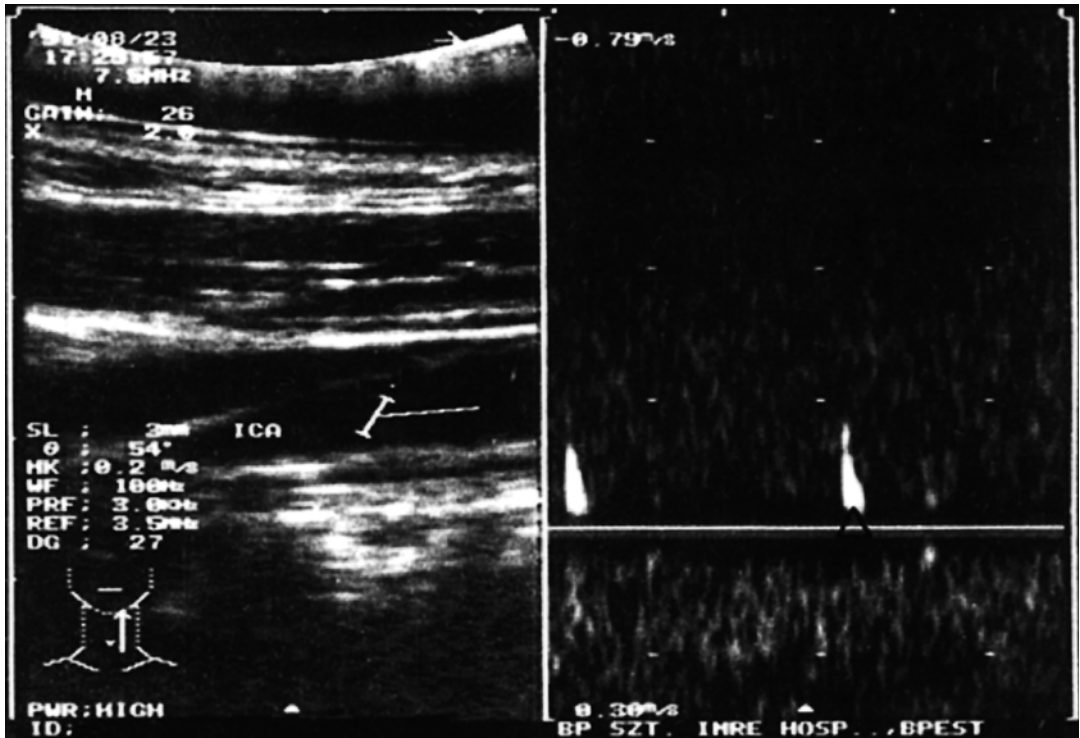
Only spikes (*empty arrow head*) can be measured at the origin of the internal carotid artery with Doppler technique; it is characteristic of the occlusion of the distal segment
